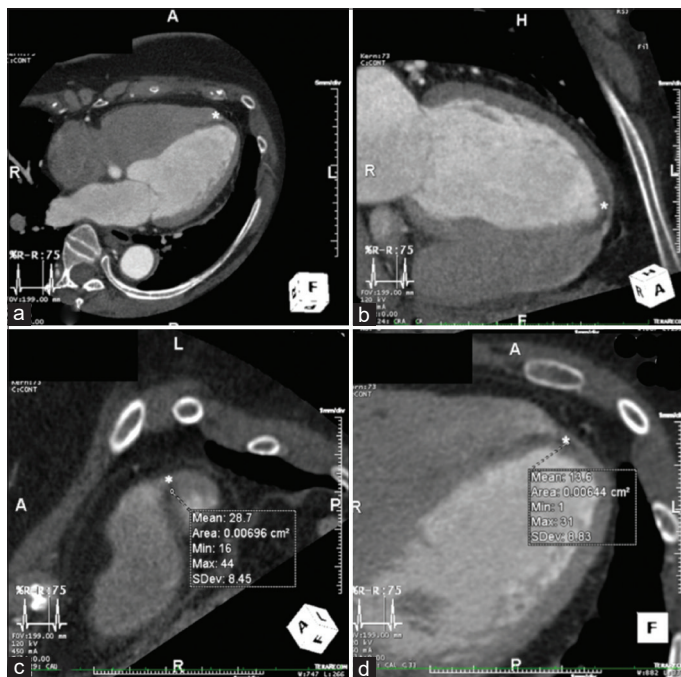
A 62-year-old woman with a previous history of unstable angina pectoris underwent a computed tomography (CT) perfusion scan during her coronary CT angiography evaluation. (a and b) There was hypodense area at the apical septal. (c and d) Hypodense area were seen at the apical septal area (asterisk) with 13.6–28.7 Hounsfield Unit
